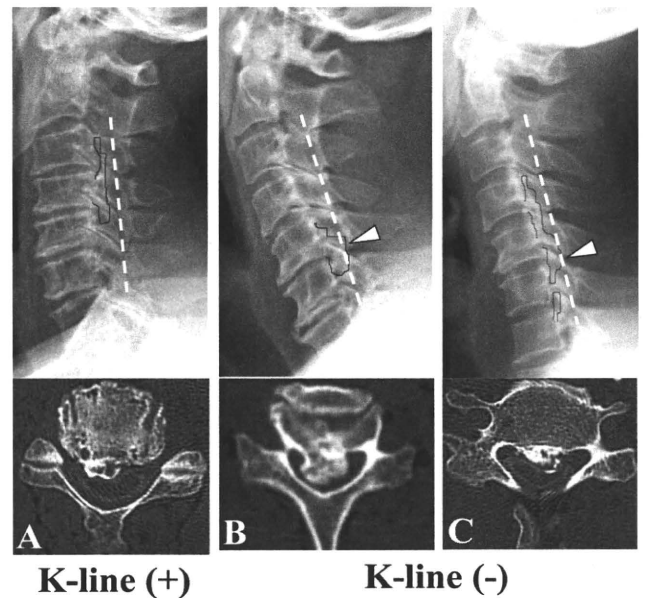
Representative cervical radiographs and computed tomography (CT) images of the K-line (+) (A) and the K-line (-) (B, C). A, The size of OPLL is not large (the occupation ratio of the spinal canal by OPLL is 36.3%, and the OPLL thickness is 4 mm at C4/5), and the OPLL stays at the ventral area of the K-line. B, The OPLL size is large (the occupation ratio is 85%, and the thickness is 11 mm at C5/6), and the OPLL extends beyond the K-line. C, The OPLL size is intermediate (the occupation ratio is 48.4%, and the thickness is 5 mm at C5/6), but the OPLL exceeds the K-line because the alignment of the cervical spine is kyphotic. Arrowheads in (B) and (C) indicate the site where the OPLL exceeds the K-line.
